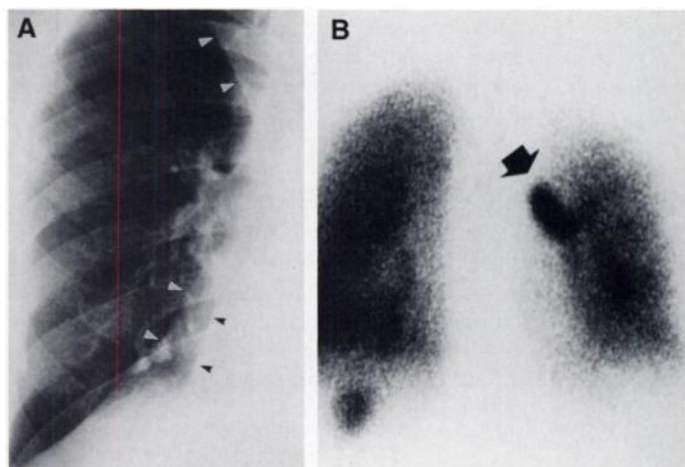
Intense, prestenotic aerosol deposition in radiographically obscure bronchial obstruction in a 31-yr-old man with chronic inflammation. (A) Posteroanterior right chest radiograph shows barely discernible, double, triangular opacities of collapsed middle lobe (lower, white arrowheads) and lower lobe (black arrowheads). Both are obscured by the cardiac shadow. Obstruction is not shown. Note the upper triangular sign, an indirect sign of lower lung collapse (upper, white arrowheads). (B) Posterior aerosol scan reveals the classic, prestenotic tracer deposition in the intermediate bronchus that is clubbed and dilated (arrow).
